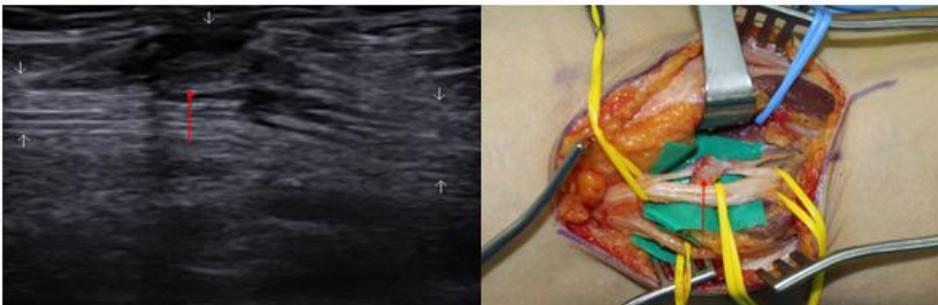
Ultrasonographic findings and intraoperative findings. Traumatic neuroma(arrow) of the left posterior tibial nerve around popliteal fossa
